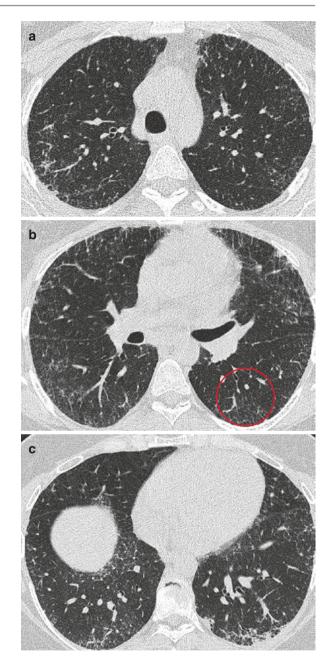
(a–c) HRCT of the lungs: subpleural reticulations
